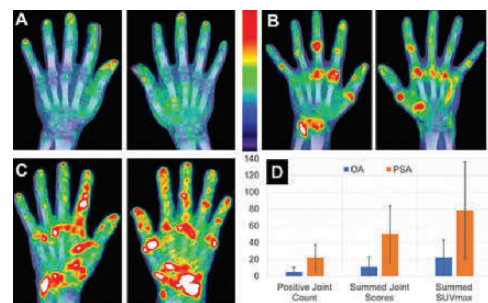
Peripheral arthritis evaluation using 18F-FDG PET/CT. Fused PET/CT scans of the hands of a participant with (A) OA, (B) RA, and (C) PsA. PET scans of PsA and RA showing extensive uptake (red to white) of the PET radiotracer, indicating inflammation. (D) Measures of joints showing positive PET features, their qualitative uptake (no, mild, moderate, or intense uptake), and their summed $rSUV_{max}$, a marker of relative glucose metabolism, hence inflammation in peripheral joints. CT: computed tomography; 18F-FDG: 18F-fluorodeoxyglucose; OA: osteoarthritis; PET: positron emission tomography; PsA: psoriatic arthritis; RA: rheumatoid arthritis; $rSUV_{max}$: relative SUV_{max} ; SUV_{max} : maximum standardized uptake value.
